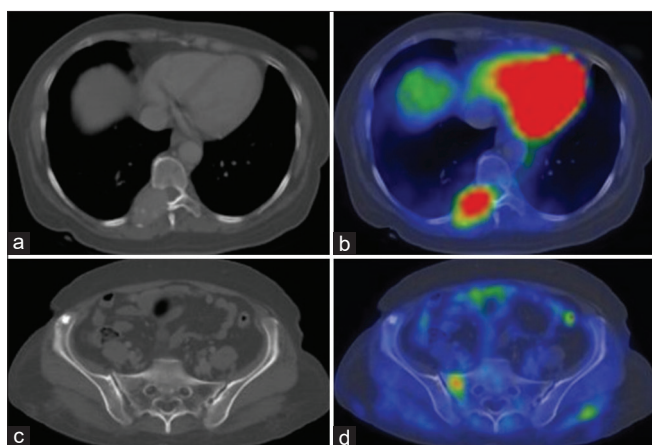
A diagnosed patient of lung carcinoma. (a) Computed tomography (CT) bone window demonstrating destructive lesion in the right pedicle and transverse process of T-10 vertebra, (b) Fused axial positron emission tomography CT (PET-CT) image showing metastatic deposit in the right pedicle and transverse process of T-10 vertebra, (c) CT finding negative for right sacral ala, and (d) fused axial PET-CT demonstrating metastatic deposit in the right sacral ala
